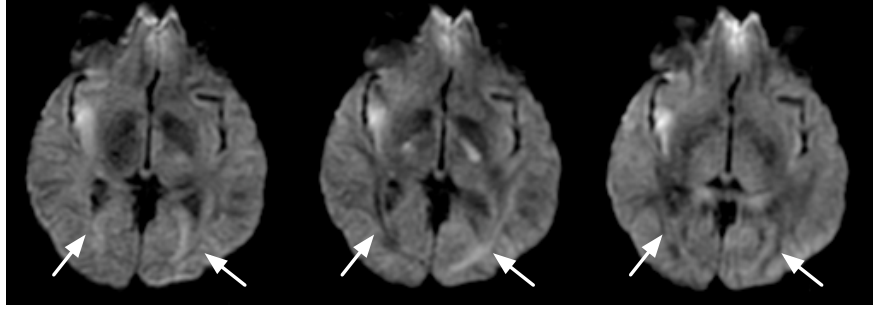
Diffusion-weighted MR images acquired with diffusion sensitisation along three orthogonal axes. The level of signal attenuation in some areas (such as those indicated with arrows) is evidently dependent on this direction. Images courtesy of Dr Susana Muñoz Maniega.
